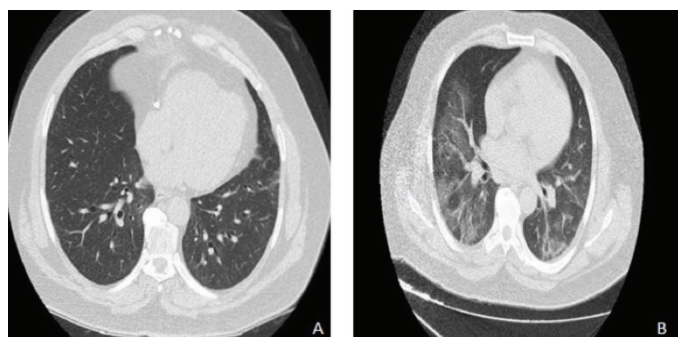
Thorax computed tomography images of the patient on April 2020 (A) and on July 2020 (B)
